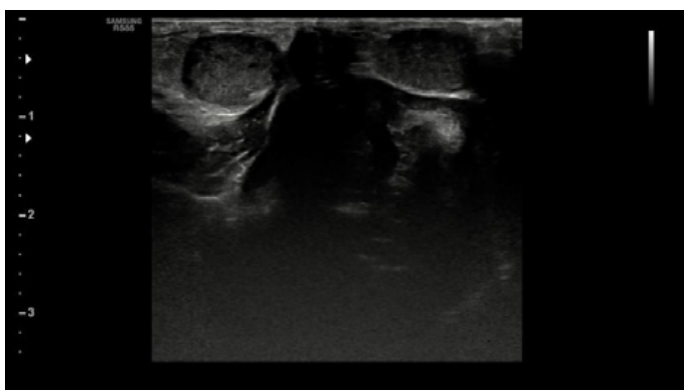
Ultrasonography of the African pygmy hedgehog. Visualization of both testicles (1) inside of the abdominal cavity and penis (2)
